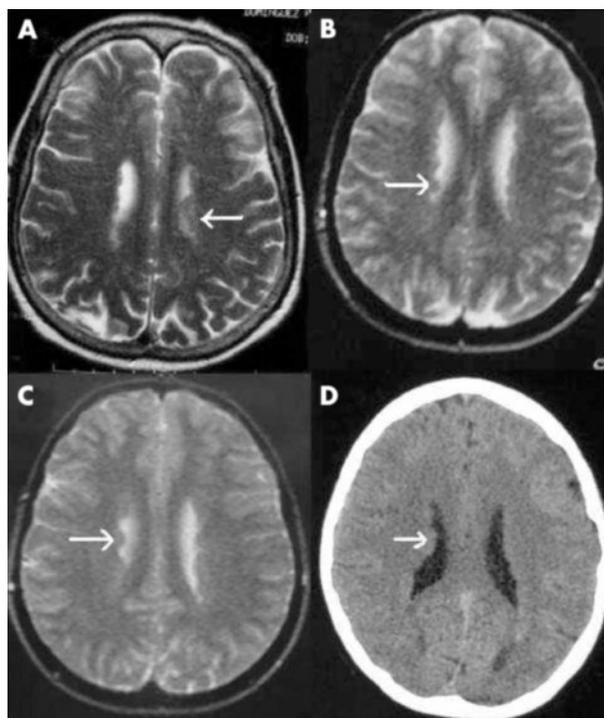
Brain magnetic resonance imaging and computed tomography (CT) showing periventricular nodular heterotopia (PNH). T2 weighted images of patient II-2 (A), III-2 (B), and IV-1 (C) show bilateral PNH. (D) Non-enhanced CT in patient III-2 demonstrates PNH. The presence of typical nodules is indicated by arrows.
